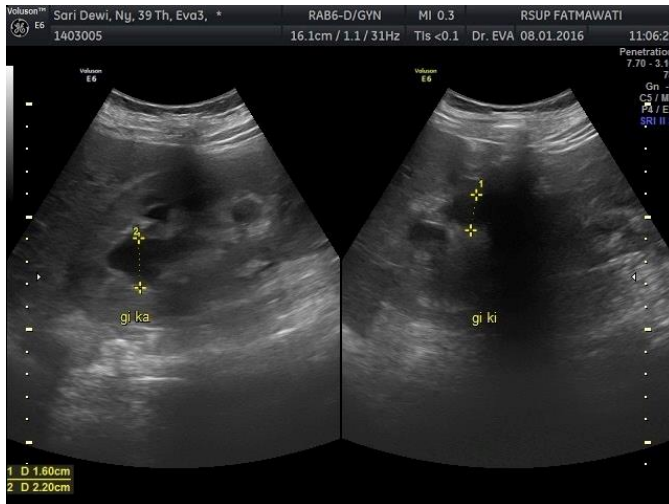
Ultrasound picture of bilateral hydro-nephrosis
